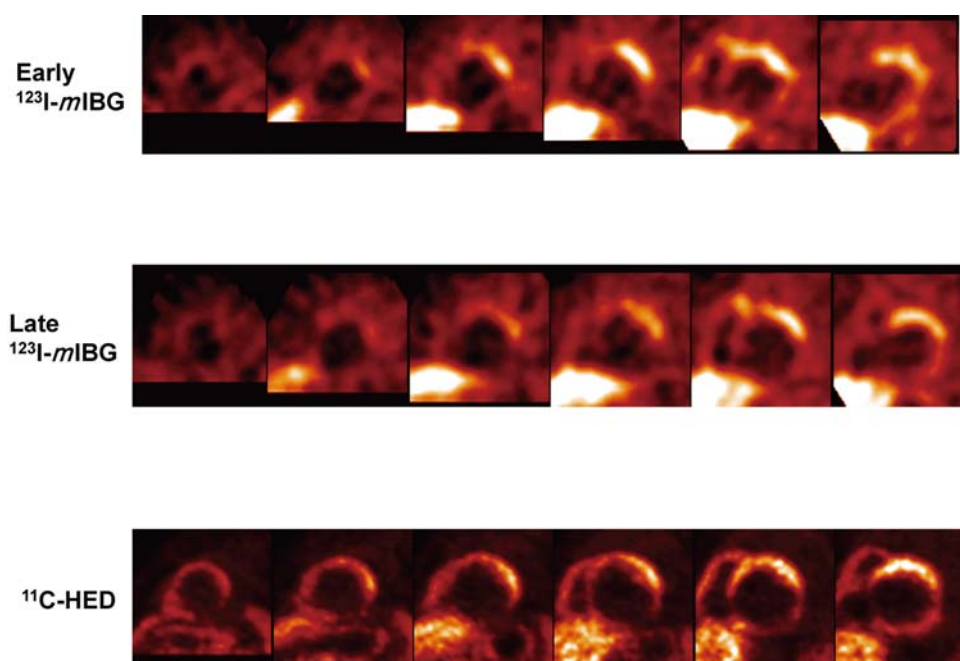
^{123}I -*m*IBG SPECT and ^{11}C -hydroxyephedrine PET/CT short-axis images showing inferior defect from a male patient with inferior myocardial infarction. HED: hydroxyephedrine.
